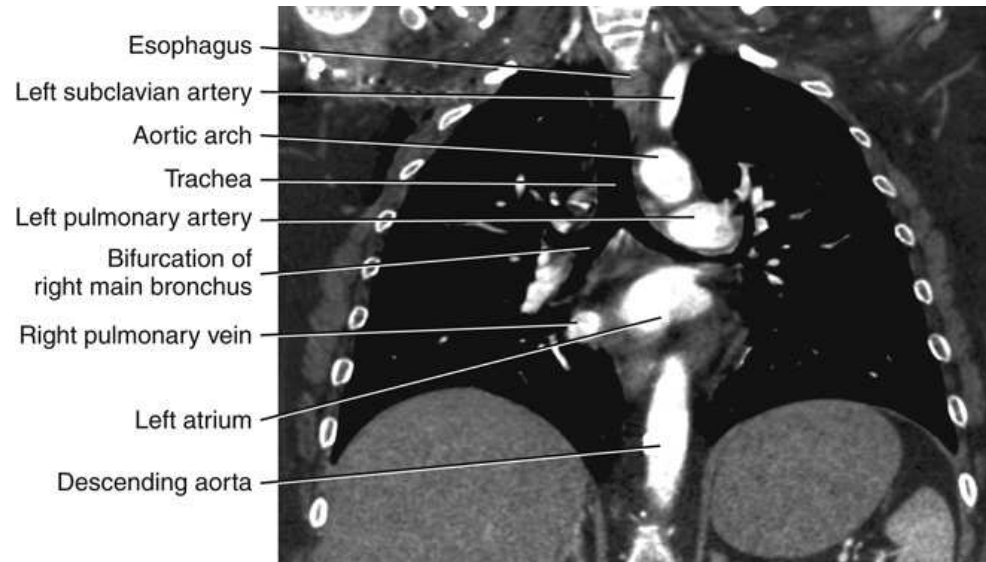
Coronal CT image of thorax corresponding to level C in Fig. 24.43.
